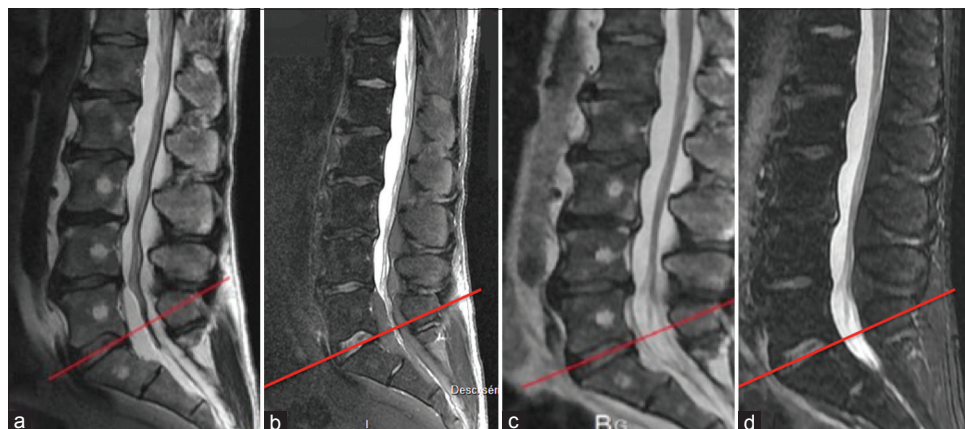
(a and b) Before and (c and d) after sagittal T2 and Stir sequence magnetic resonance imaging demonstrating less epidural lipomatosis after 7 months of dietary planning
